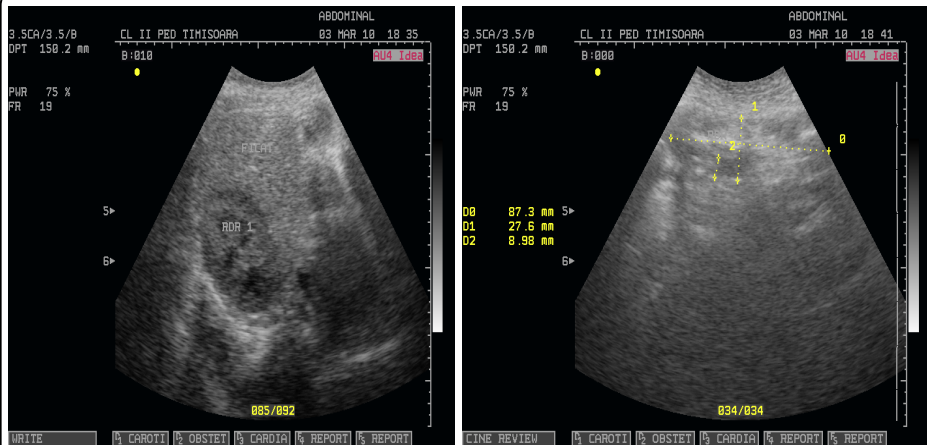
Abdominal ultrasound: the absence of the left kidney in the renal fossa.
